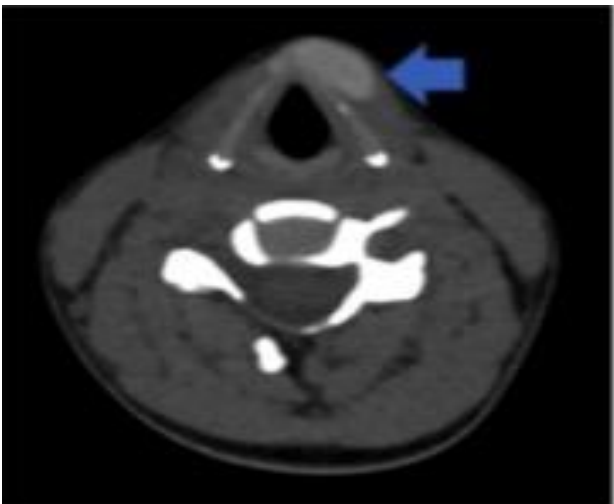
Axial computed tomography neck showing ectopic thyroid at the infrahyoid region.
